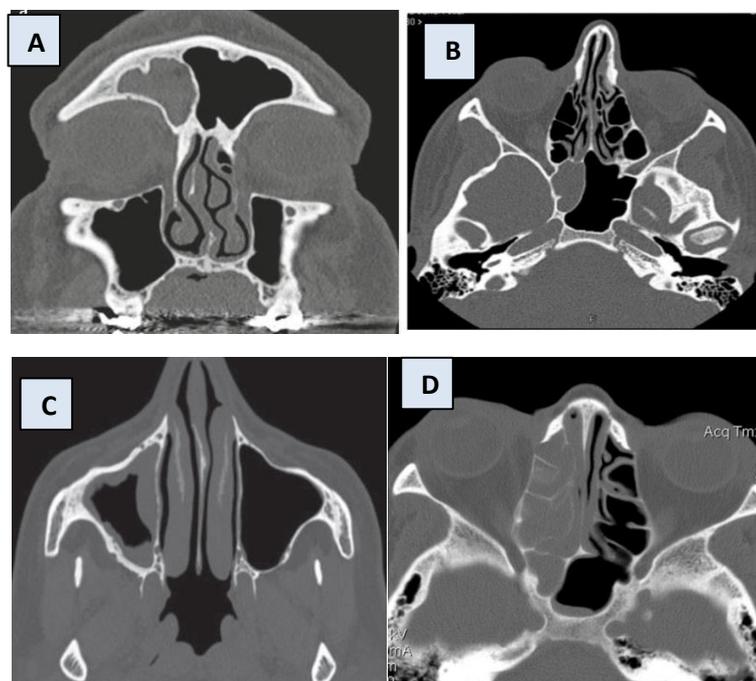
Axial CT image shows Chronic sinusitis in A/ Rt. Frontal sinus B/ Rt. sphenoid sinus C/ Rt. Maxillary sinus D/ Rt.ethmoid sinus (Cuenca, Valentín et al. 2020).(Mafee, Farid et al. 2014)
